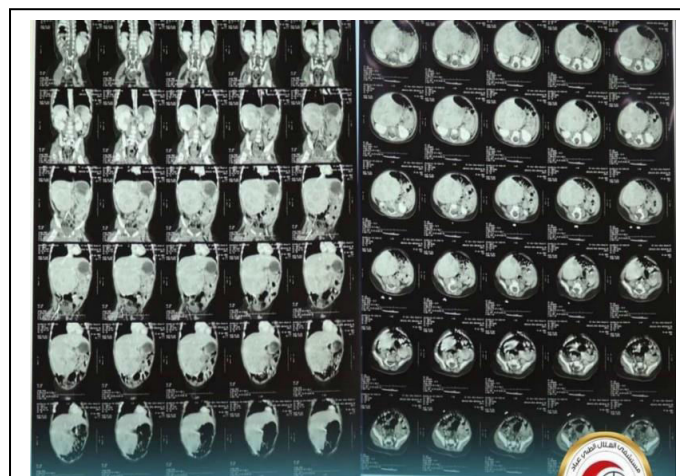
CT scan showing mass at Right lobe of Liver, Figure (1).
